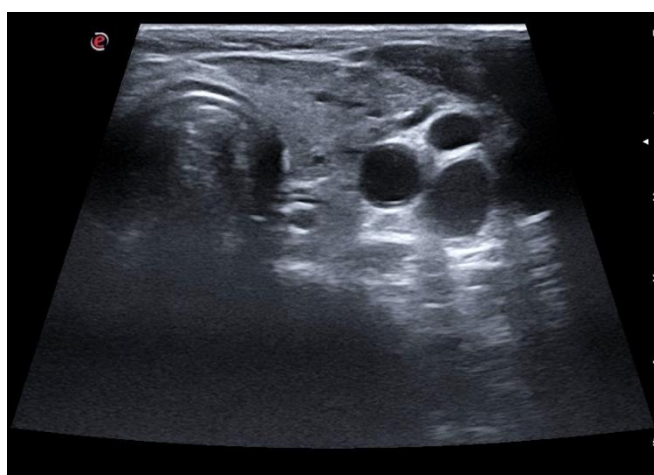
Ultrasonography image of Papillary carcinoma of thyroid
